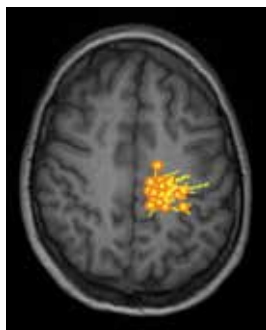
Cluster of MEG dipoles from one data set. One data set out of 15 two-minute data sets showed a cluster of 26 MEG dipoles fulfilling criteria (see section 3.3) from 43 MEG spikes, which was localized in the left Rolandic region transparently shown on axial MRI.
